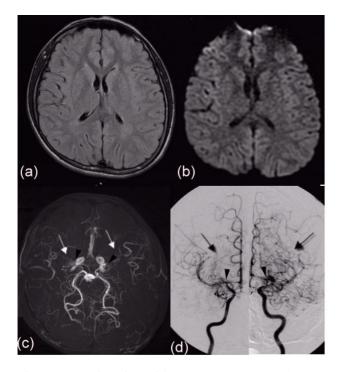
MR imaging with (a) Water suppressed proton (FLAIR) imaging. (b) Axial DWI of the brain showed no abnormal findings before the operation. (c) MR angiography showed significant narrowing of the supraclinoid portion of both distal internal carotid arteries (arrow) and abundant collaterals from the bilateral posterior cerebral arteries (arrow head) (d) Bilateral internal carotid angiography demonstrated both supraclinoid carotid narrowing (arrow) with a "puff of smoke" appearance of the collateral vessels (arrow head) in the neighborhood of the stenotic area.
